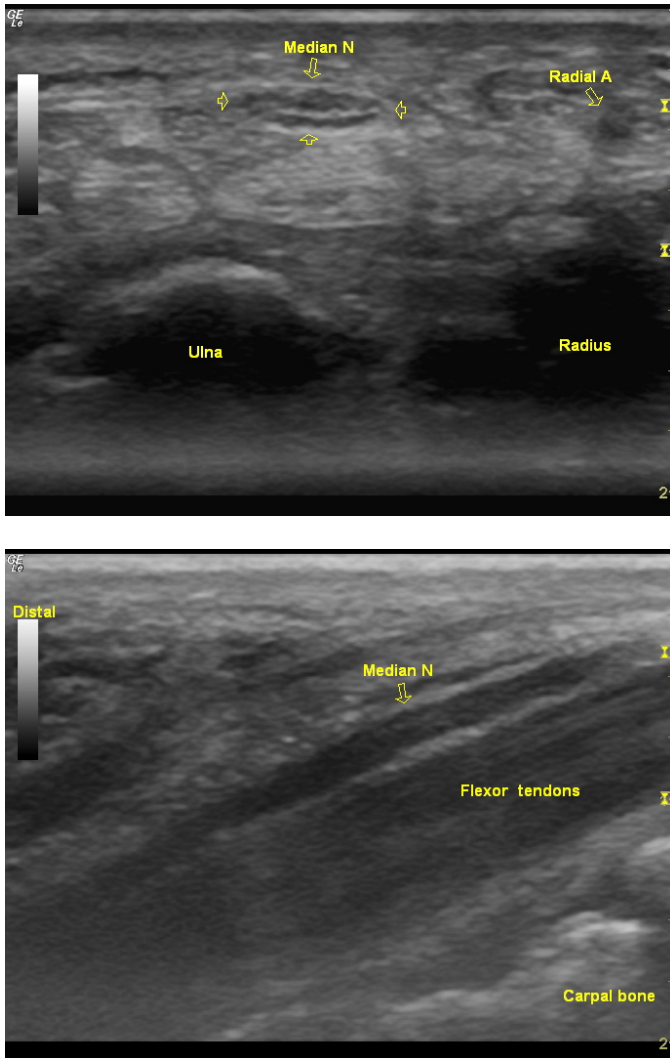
Normal appearance of the median nerve at the carpal tunnel. On the top is a transverse sonogram of the median nerve at the level of the distal wrist crease, showing the nerve surrounded by flexor tendons. The cross-sectional area of the nerve is 0.08 cm^2 (normal $< 0.10 \text{ cm}^2$). On the bottom is a longitudinal sonogram of the median nerve across the proximal carpal tunnel. The maximum anteroposterior diameter of the nerve is 0.16 cm .
